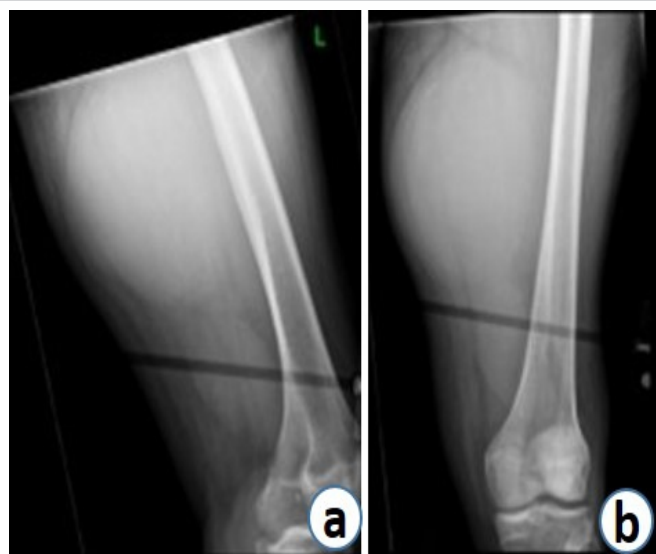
A plain radiograph of the left thigh on initial presentation, (a) lateral view and (b) AP view.
